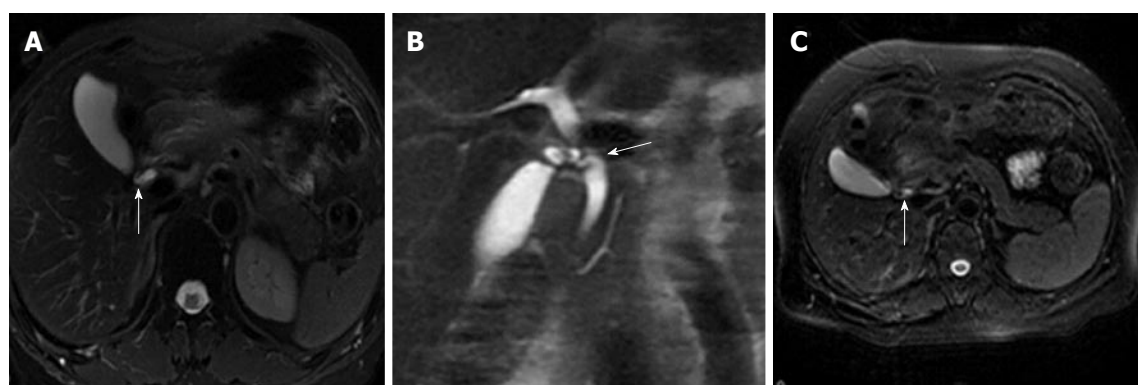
The cystic junction radial orientation. An FRFSE T2-weighted image (A) shows lateral insertion of the cystic duct (arrow). A coronal SSFSE T2-weighted image (B) shows medial insertion of the cystic duct (arrow). An FRFSE T2-weighted image (C) shows posteroanterior insertion of the cystic duct (arrow). SSFSE: Single-shot fast spin-echo; FRFSE: Fast-recovery fast-spin echo.
